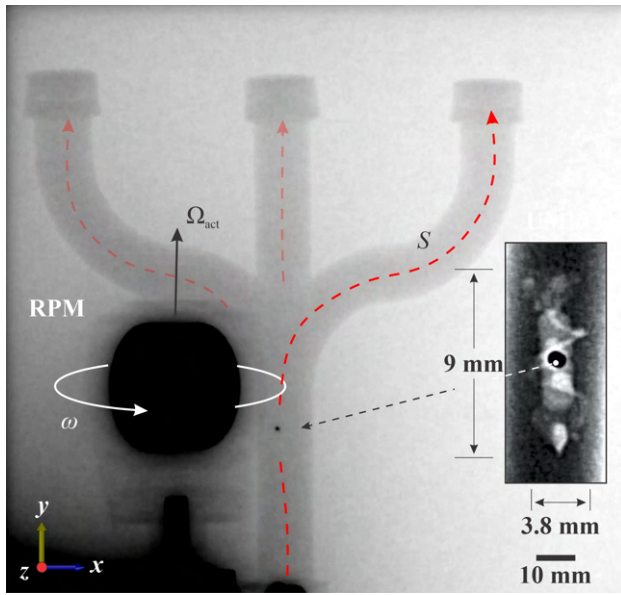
An X-ray Fluoroscopy image captures a UMR navigating within a curved lumen. The curvature of the lumen is defined by the tangent angle ($\psi(S)$) relative to the arc length S . The UMR's movement involves a dual action: rotation of the RPM around the rotation axis Ω_{act} and controlled steering facilitated by in-plane torque applied about the z -axis. The inset shows the UMR visualized through the utilization of a radiocontrast agent.
